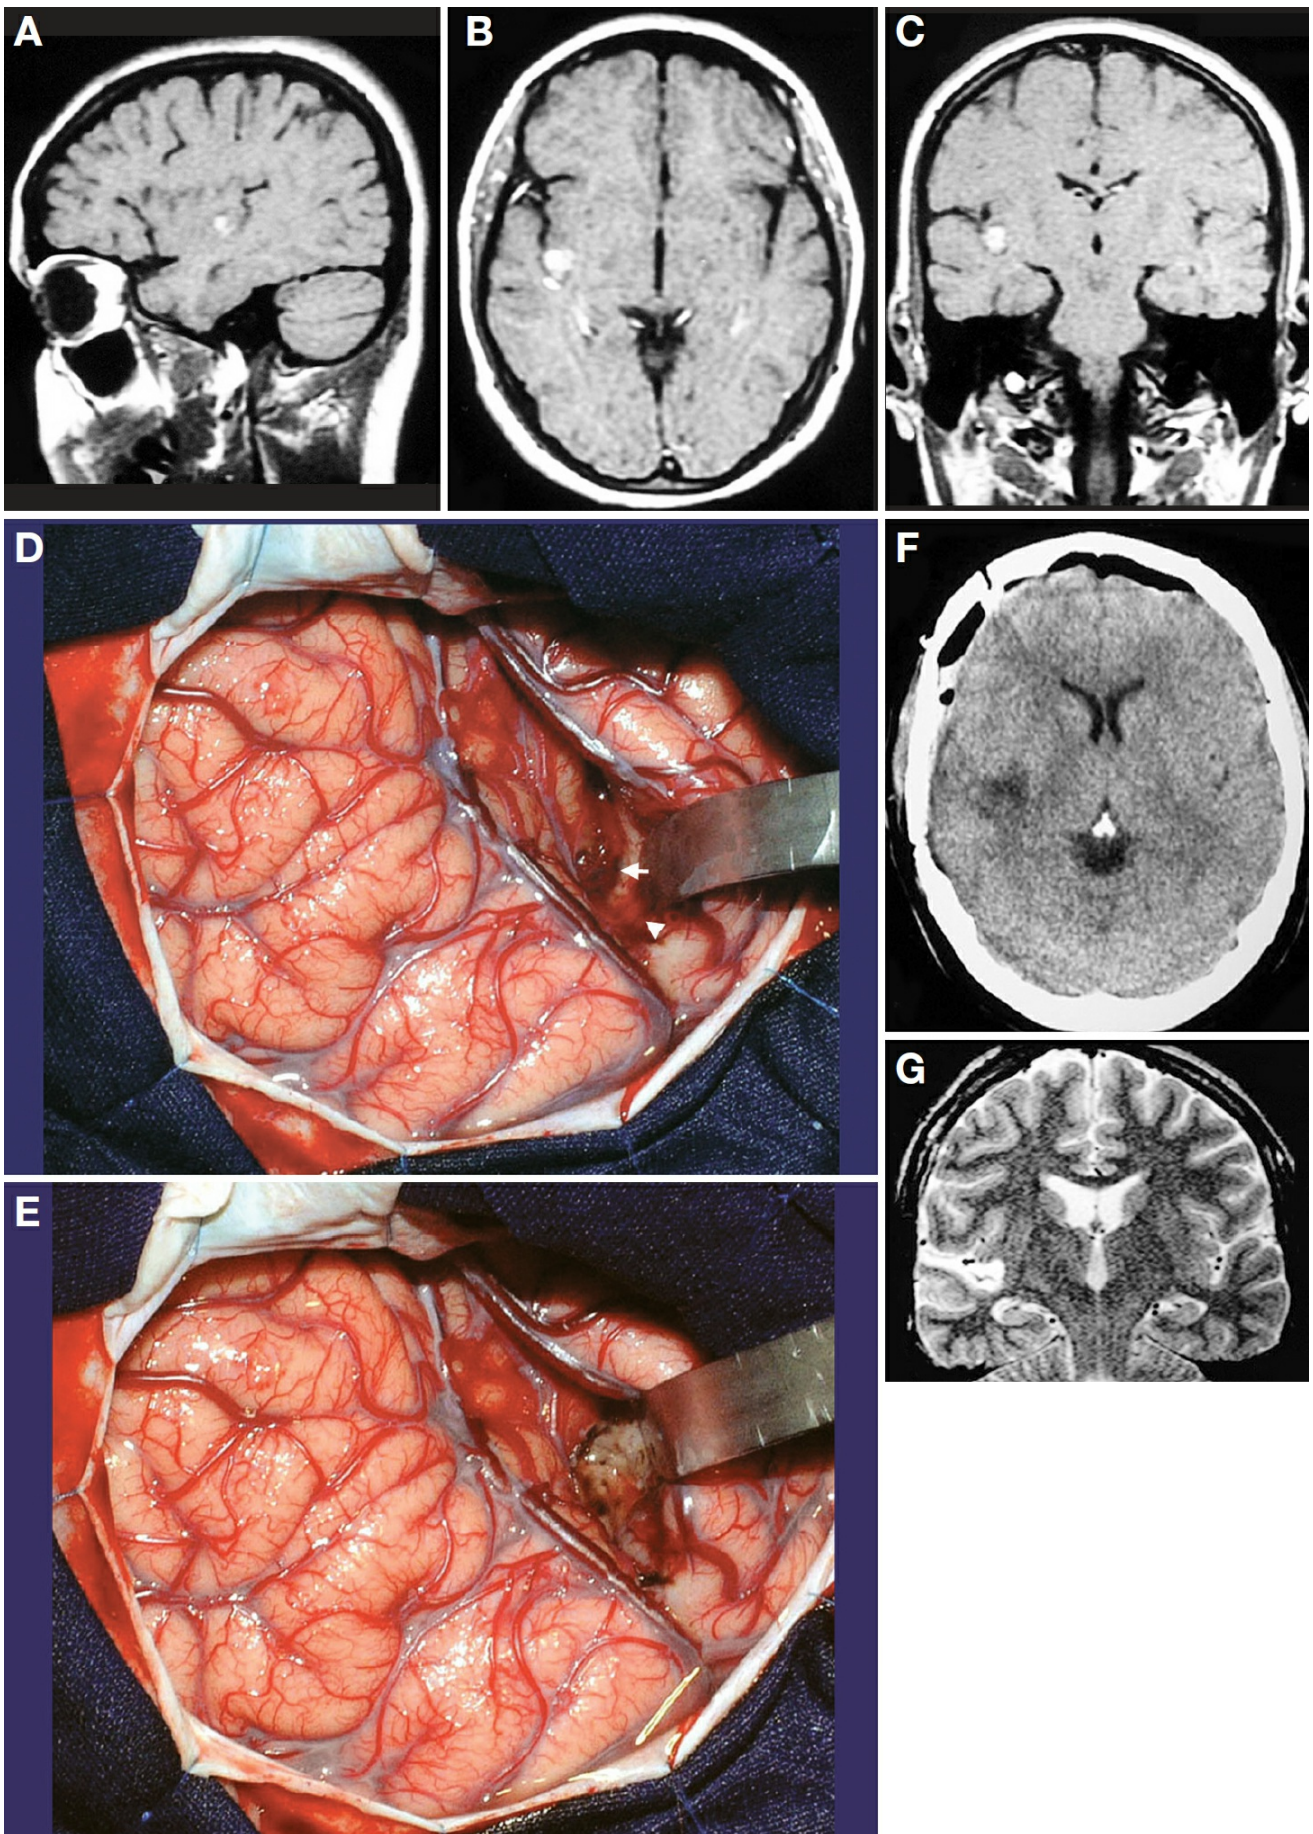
A, sagittal MRI scan depicting a cavernoma located in the long gyrus of the insula, approximately halfway between the superior and the inferior limiting sulci. B, axial MRI scan. C, coronal MRI scan. D, intraoperative photograph after the right pterional transsylvian approach.
